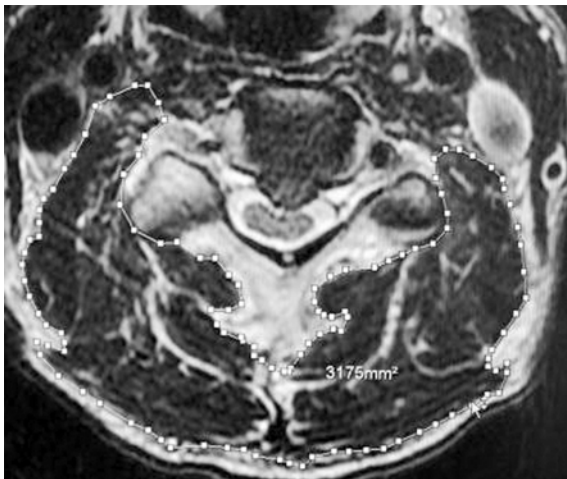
Measurements of the cross-sectional areas of the cervical posterior muscles on axial T2-weighted magnetic resonance images at the level of C4/C5.
